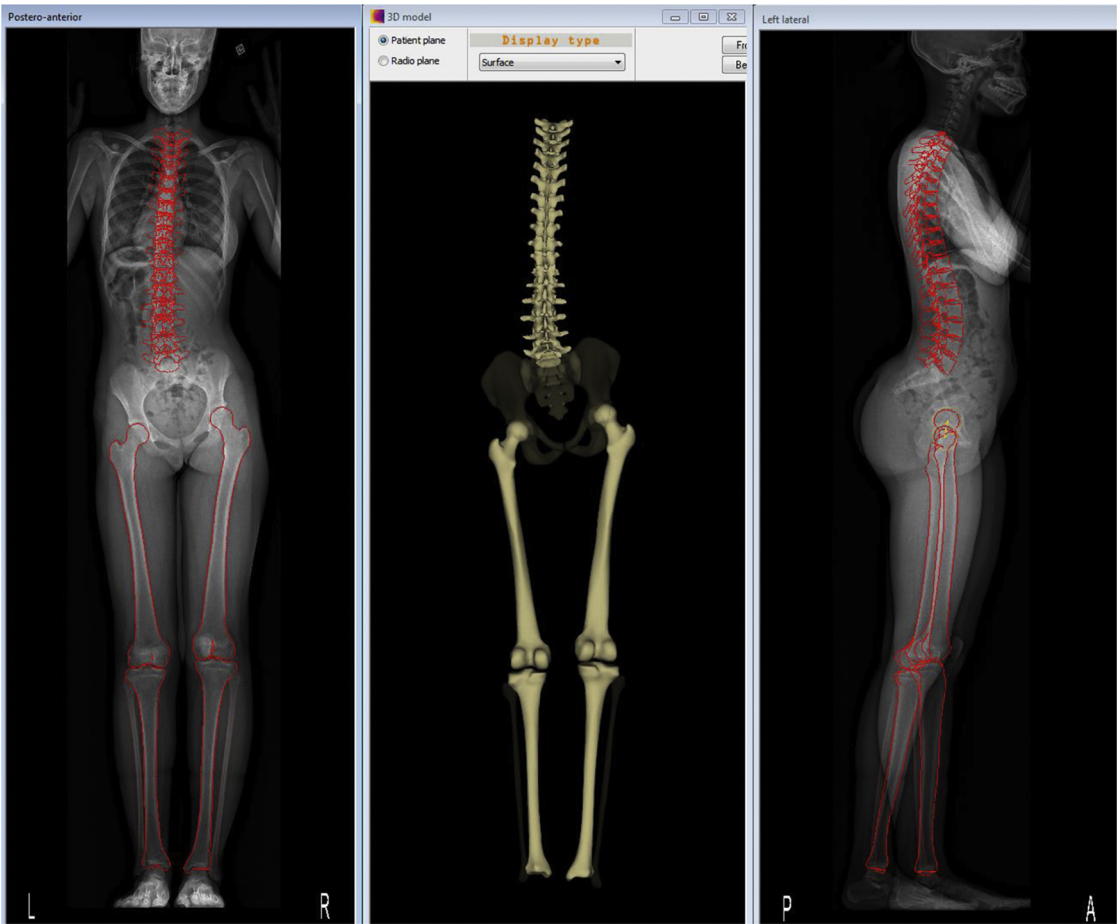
Frontal and lateral biplanar X-rays of the same patient in the standing position (left and right) and after skeletal reconstruction (middle).
